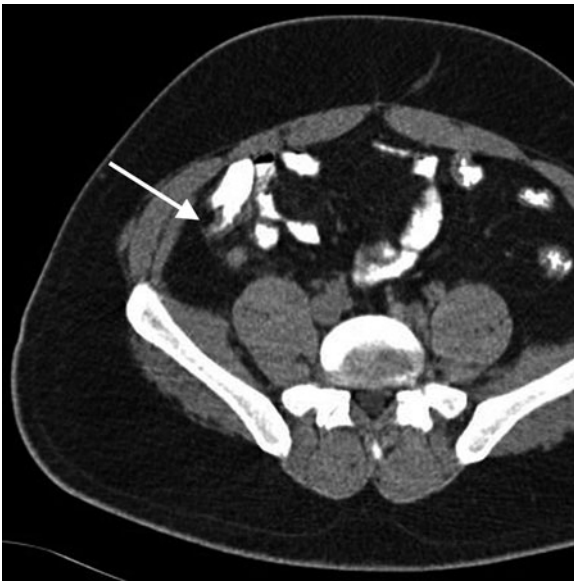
CT image obtained with oral contrast in a patient with a definite diagnosis of acute appendicitis demonstrates the so-called *arrowhead sign* (arrow)
